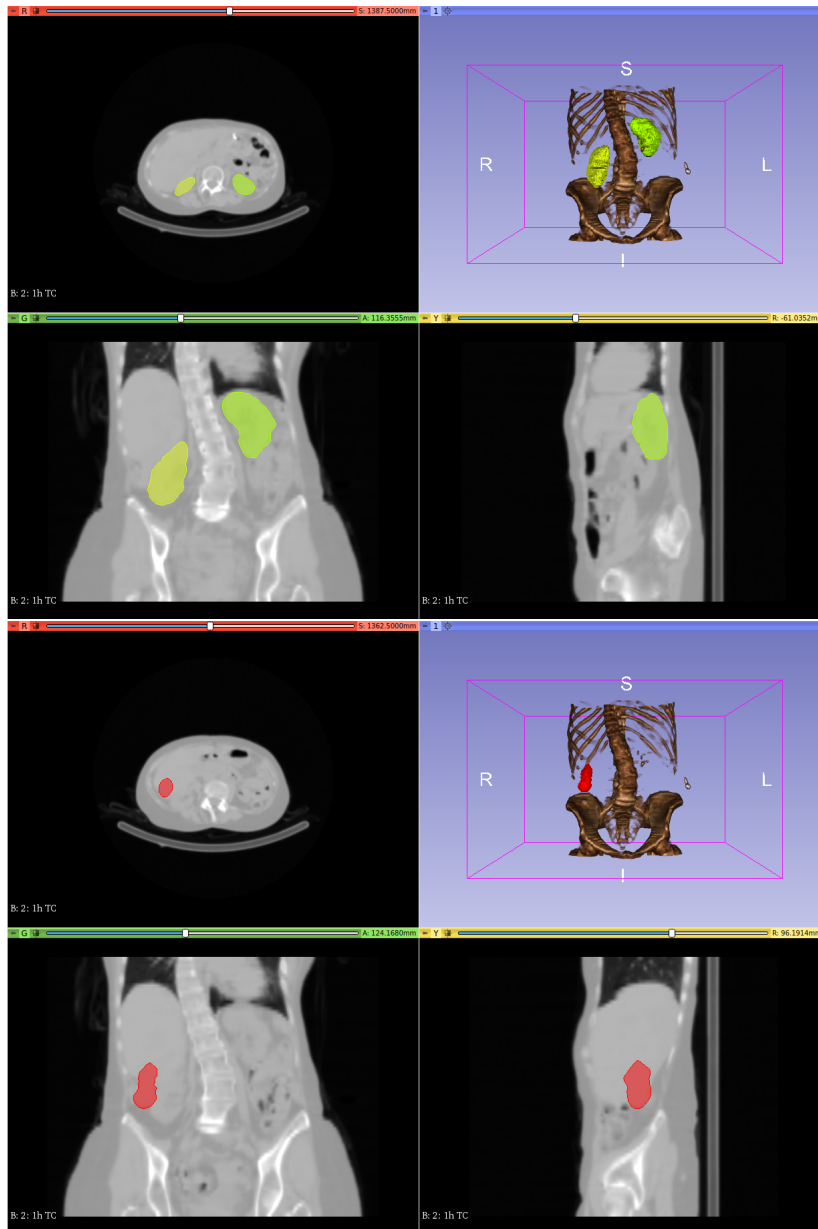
Patient 9 CT and SPECT images imported into 3D Slicer with the RT structures of kidneys (yellow, top) and the tumor (red, bottom).
